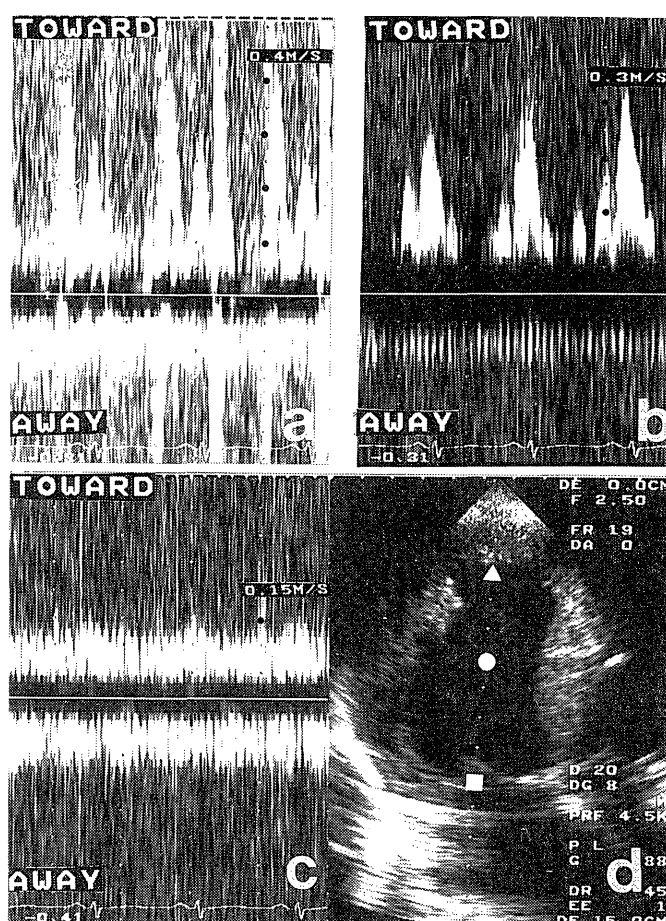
Pulsed Doppler echocardiography demonstrates normal two peaks of the transmitral inflow pattern when the sampling volume is placed just above the closure point of the mitral valves (Fig 7-a, d). When displacing the sampling volume at the center of the left ventricular cavity, the velocity of the rapid filling is lower than that of the atrial contraction (Fig 7-b, d). Bidirectional, disturbed flow is observed with shifting the sampling volume at the apex. (Fig 7-c, d), The site of the sampling volume of Figure. a, b, c is noted as the white sign of square, circle and triangle respectively.
